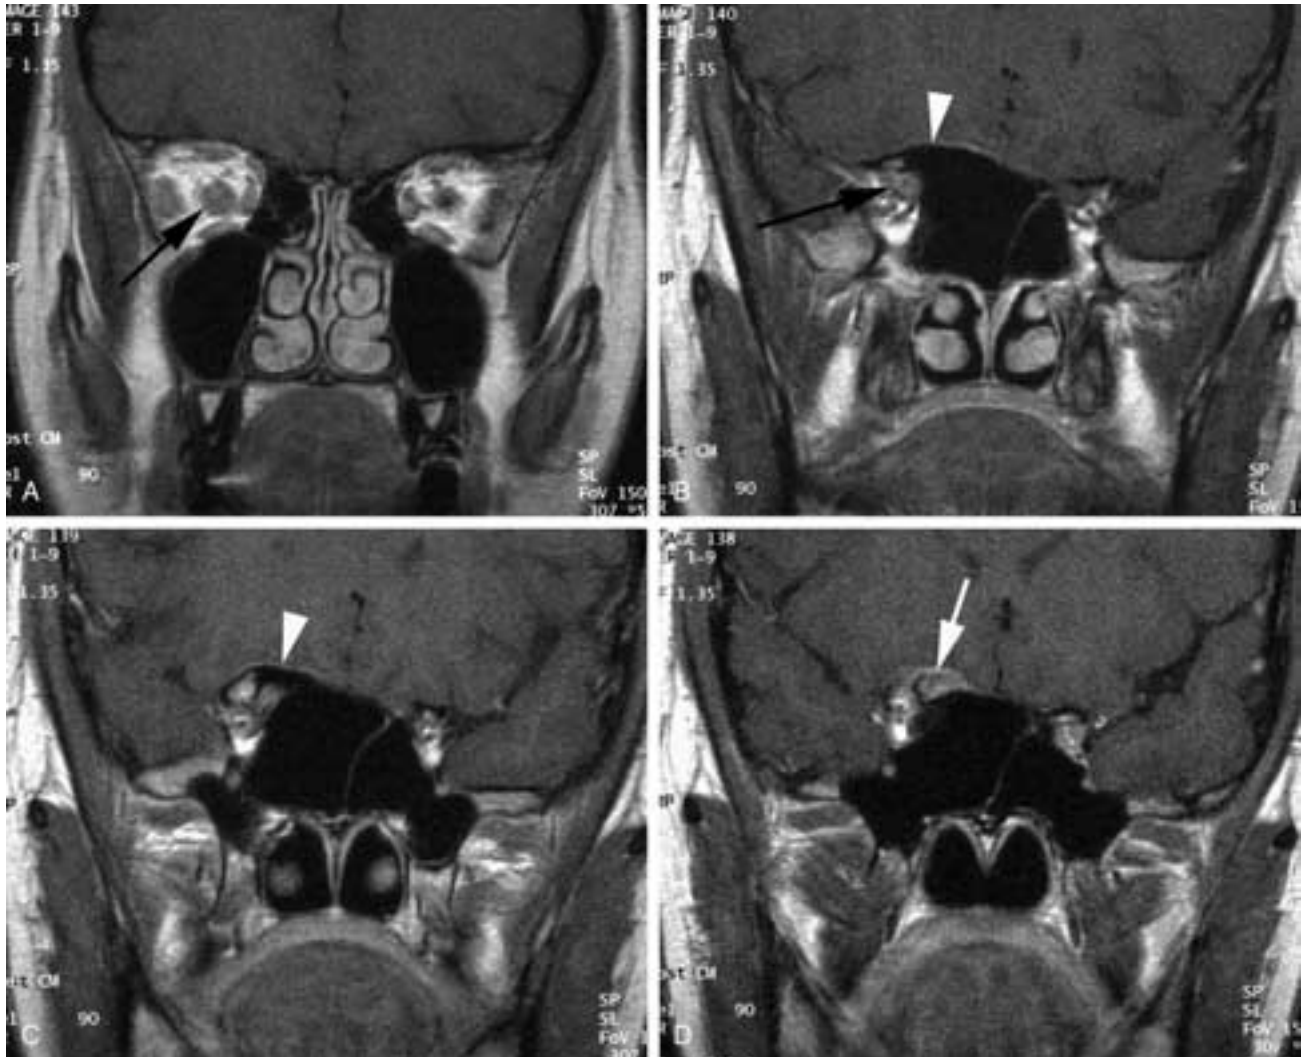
Pneumosinus dilatans of the sphenoid sinus with optic nerve meningioma. T1-weighted postgadolinium coronal images. A, Meningioma of the optic nerve sheath (arrow). B, Anterior to the optic foramen; enlargement of the nerve sheath (black arrow) and enlargement of the sphenoid sinus (arrowhead). C, Dilation of the air cell (arrowhead) extending into the anterior clinoid. D, The meningioma (arrow) extends intracranially at the opening of the optic canal.
